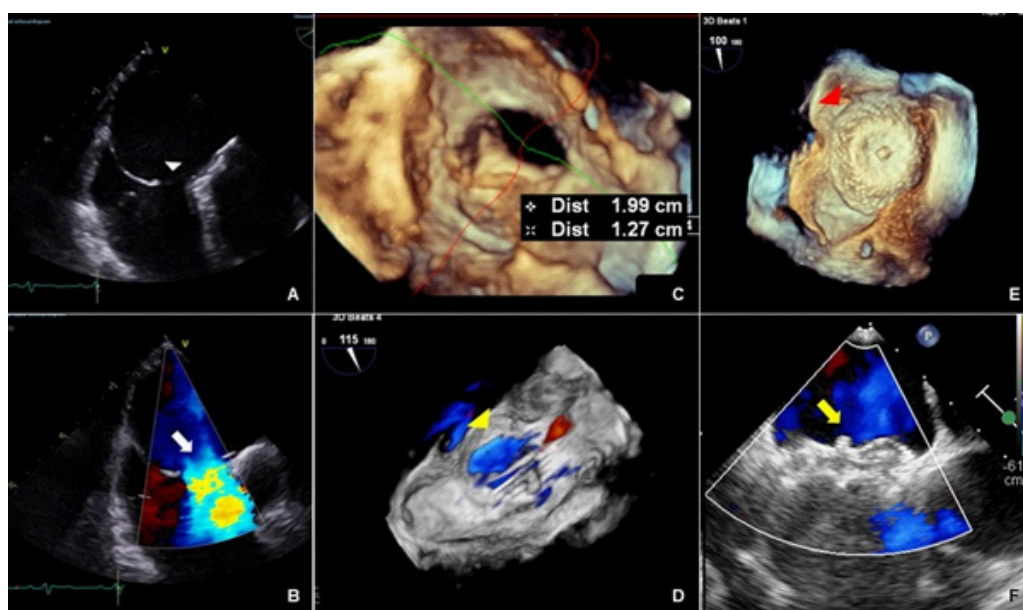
(A,B) Transoesophageal echocardiogram (TOE) 2D images showing the large atrial septal defect (ASD) (white arrowhead) with a large left-to-right shunt (thick white arrow). (C,D) 3D TOE images showing the exact dimensions of the ASD and the large shunt (yellow arrowhead). (E,F) TOE images post-ASD closure showing a well-seated occluder device on 3D view from the right atrial aspect (red arrowhead), with no residual flow demonstrated on color Doppler (yellow arrow).
